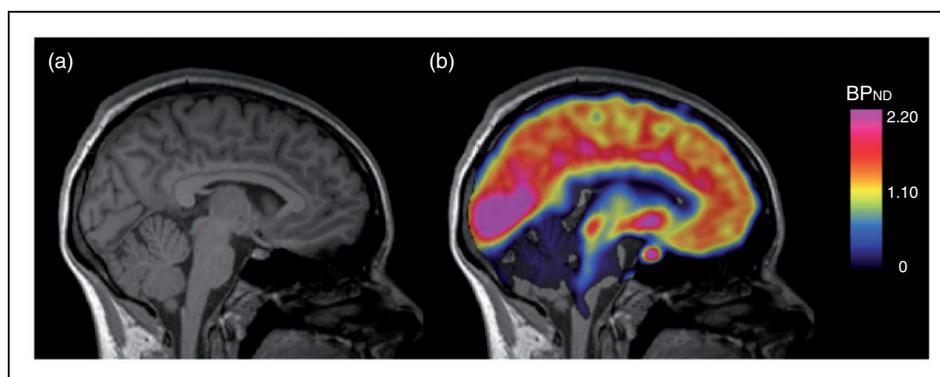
Parametric image of 5-HT_{1B} receptor binding. (a) Structural T1-weighted MRI image. The 5-HT_{1B} binding is not identifiable. (b) [¹¹C]AZ10419369 PET image superimposed on the corresponding structural image, highlighting the 5-HT_{1B} system.
